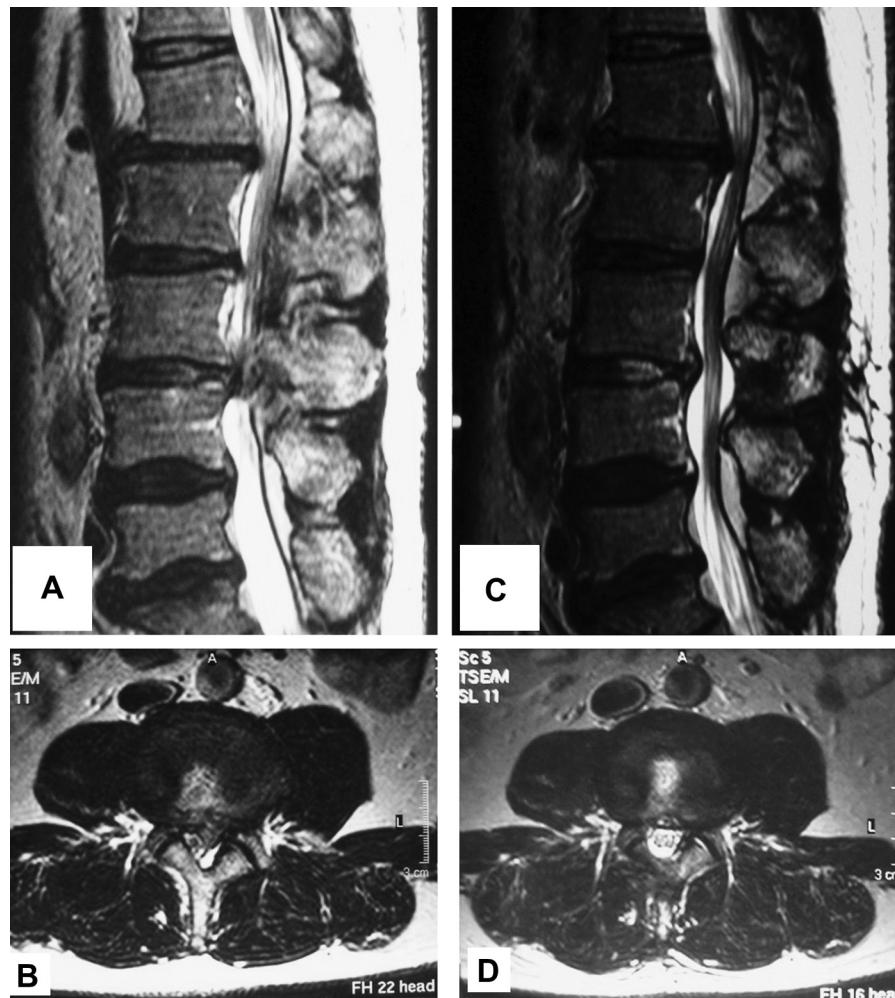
(A, B) Posterior epidural migrated lumbar disc fragments were observed at L3–L4 on T2-weighted magnetic resonance imaging at the first visit. (C, D) Magnetic resonance imaging showed the disappearance of the posterior epidural migrated lumbar disc fragments 3 months after surgery.
